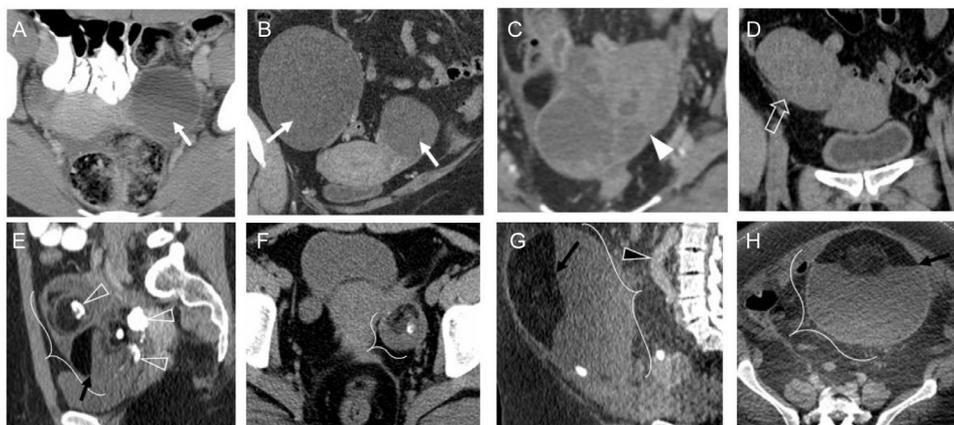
Cystic and solid ovarian neoplasms are often first detected incidentally with CT as benign and malignant ovarian masses are often asymptomatic. (A) axial CT image shows a simple 5 cm cyst (arrow) in a 24-year-old woman which requires no follow-up imaging. (B) coronal CT image shows 12 and 7 cm simple ovarian cysts (arrows) in a 50-year-old woman which require additional characterization with US. (C) coronal CT image shows an enhancing cystic and solid ovarian mass consistent with ovarian cystadenocarcinoma (arrowhead). (D) coronal CT image shows a solid right ovarian mass determined to be a granulosa cell tumor (open arrow) at surgical pathology. (E) sagittal CT image shows a complex solid and cystic mass with coarse calcifications and fat fluid levels consistent with a mature cystic teratoma (bracket). (F) axial CT image shows a small left ovarian mass with fat, soft tissue, and calcification compatible with mature cystic teratoma (bracket). (G) and (H) sagittal and axial CT images show a large ovarian mass with a fat fluid level (bracket) in a women presenting with acute right lower quadrant pain. The appendix was dilated and inflamed at laparotomy found a ruptured cystic teratoma with secondary appendicitis (black arrowhead).
